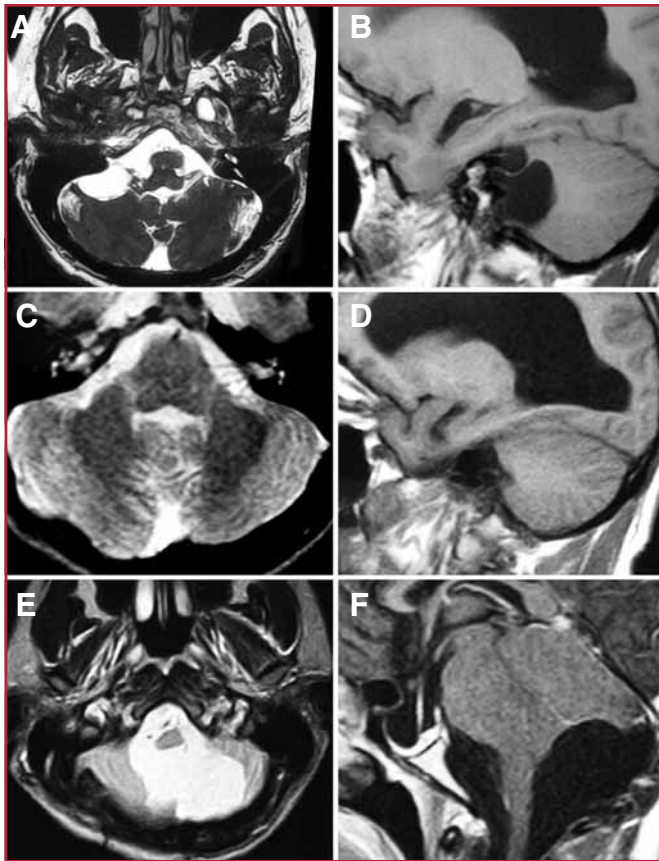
Pre- and postoperative magnetic resonance imaging (MRI) scans of enterogenous cysts (ECs). A and B, T1- and T2-weighted MRI scans showing a multiloculated T1 hypointense and T2 hyperintense cystic lesion without contrast enhancement, within the right pontocerebellar angle extending contralaterally and toward the cerebellar vermis. C and D, T1- and T2-weighted postoperative MRI scans demonstrating the disappearance of the cystic lesion within the cerebellopontine angle. E and F, T1- and T2-weighted MRI scans obtained 4 months after surgery showing the EC recurrence within the posterior fossa causing severe brainstem compression.
